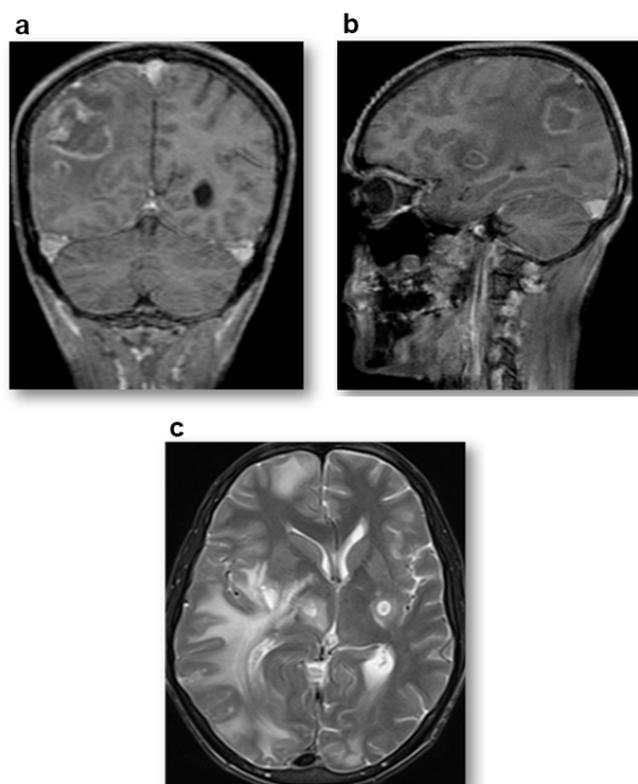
a) MRI showing cerebral toxoplasmosis on right frontoparietal region – sagittal section. b) MRI T1 image (coronal section) showing multiple lesions. c) T2 weighted image showing cerebral toxoplasmosis.
